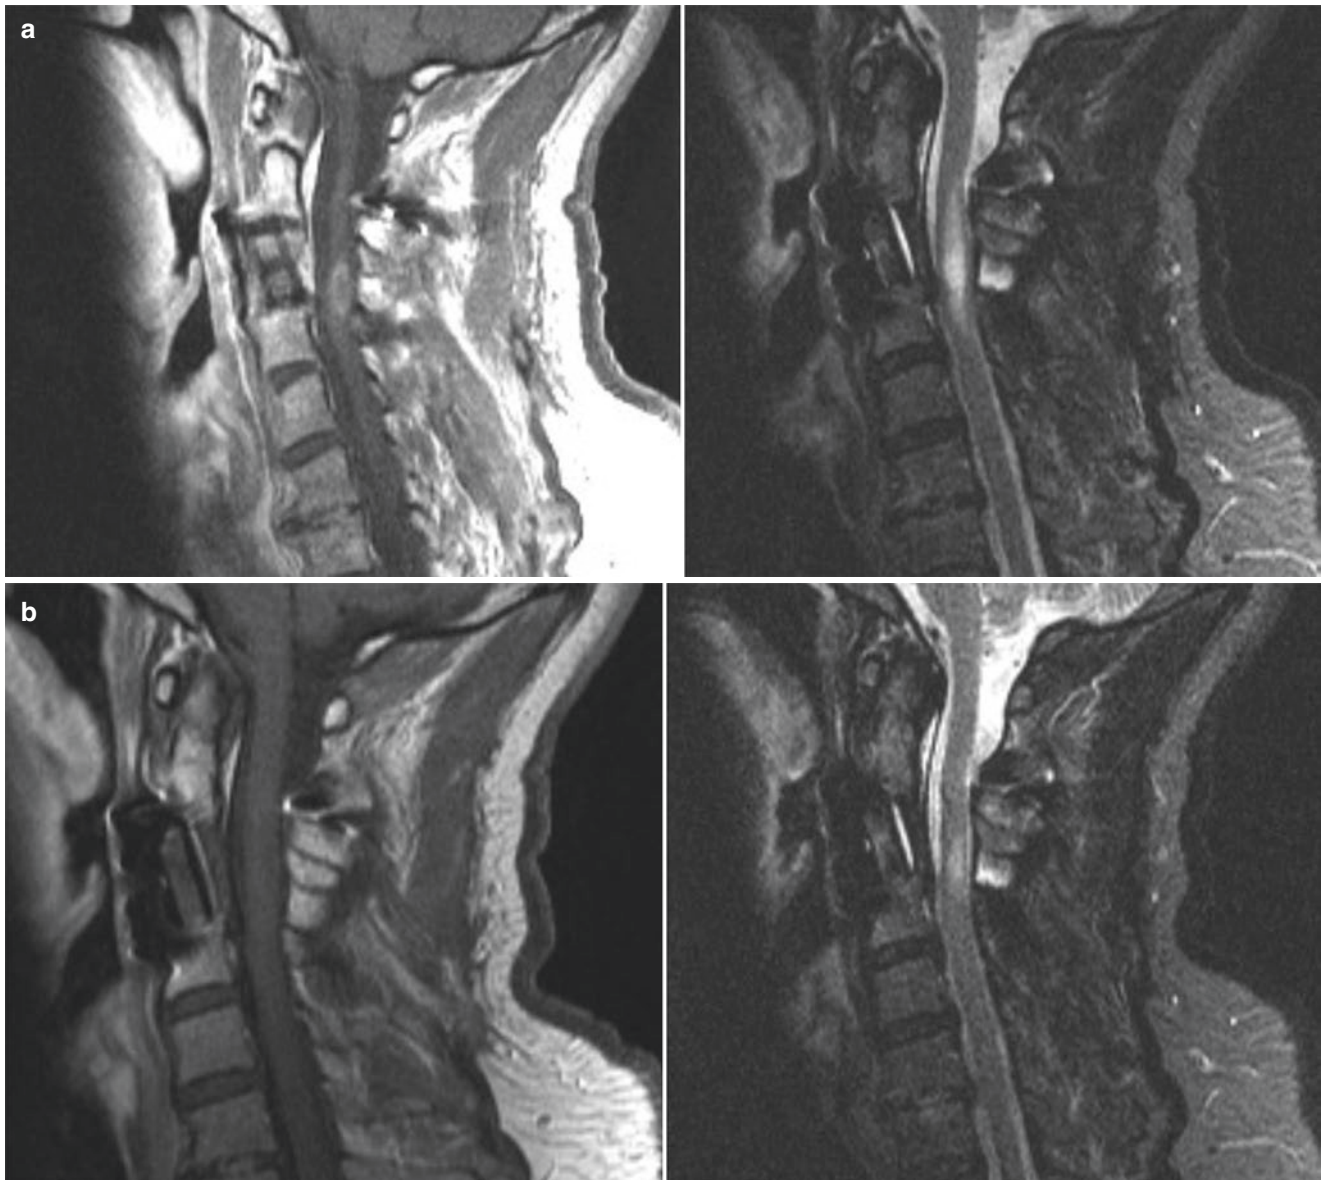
(a, b) 53-year-old with a chordoma s/p C3 corpectomy, followed by adjuvant SRS to 16 Gy. (a) MRI 3 months later showed enhancement and edema in the cord consistent with spinal cord myelopathy.
